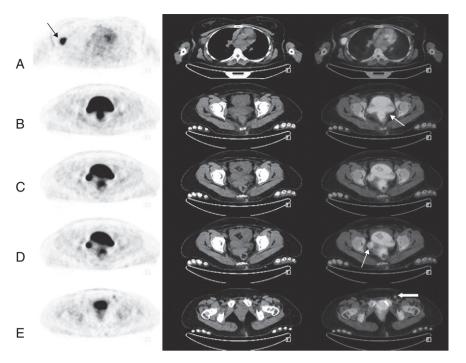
Axial PET, CT and PET/CT fusion images demonstrate axillary lymph node (arrow) (A), increased uptake in cervical region (arrows) (B,C,D) and left inguinal nodal uptake (arrow) (E).
